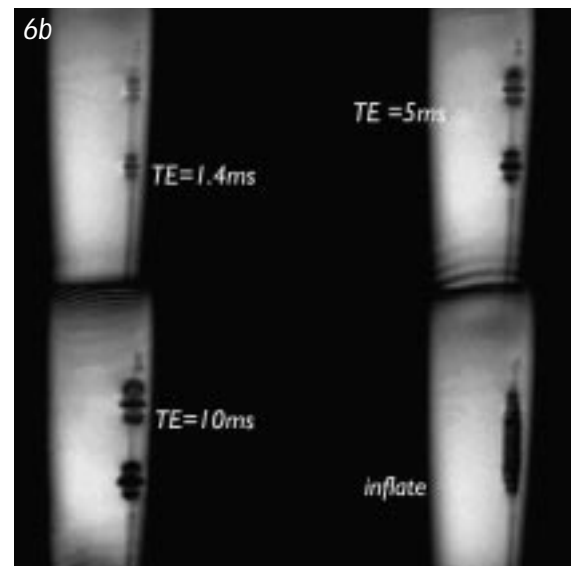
A balloon catheter (Cordis, Roden, the Netherlands) with dysprosium labels at the proximal and distal ends. The labels produce field disturbances and signal voids. Imaging sensitivity can be adjusted with the echo time, TE. Once positioned, balloon deployment can be visualized by MRI.
